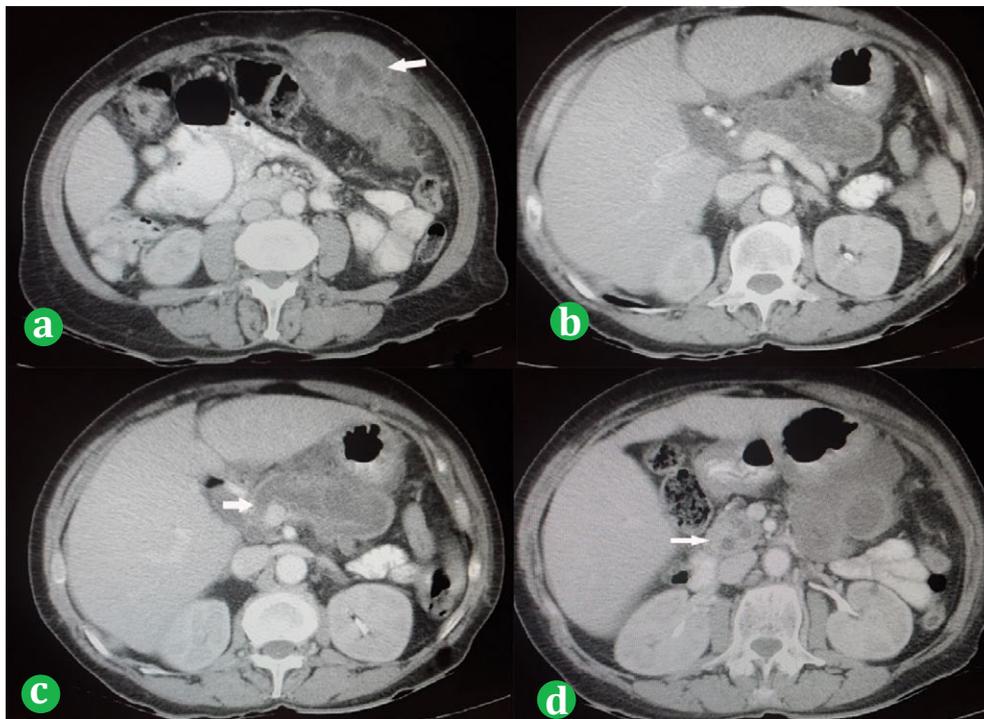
(a). CT scan, white arrows points supra-aponeurotic collection. (b). CT scan with cystic mass behind the stomach which involves the pancreas body. (c). White arrow shows Wirsung duct dilation. (d). White arrow points uncinate process with pancreatic duct dilation.
